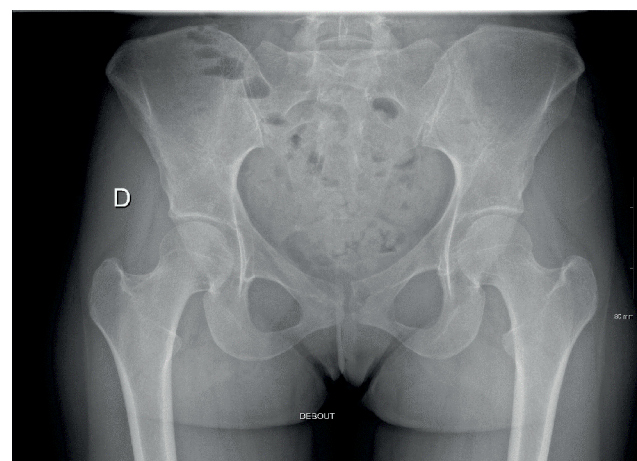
22 years old Female with external snapping hip, standard radiograph Face basin.
